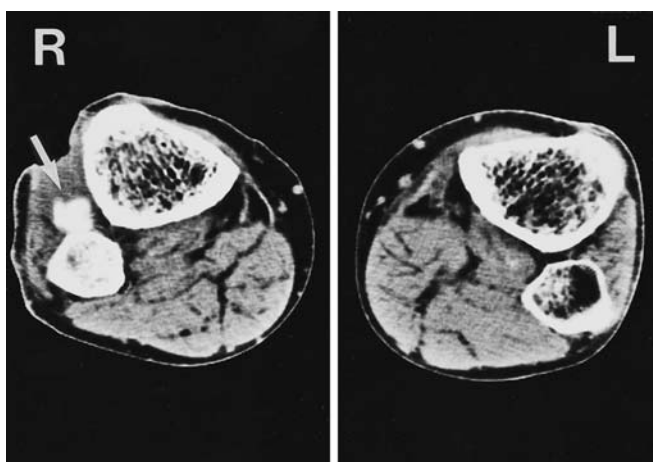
Computed tomography images with arthrography of both legs, 2 weeks after the operation, showing leakage of the contrast agent into the right anterior compartment (*arrow*)
